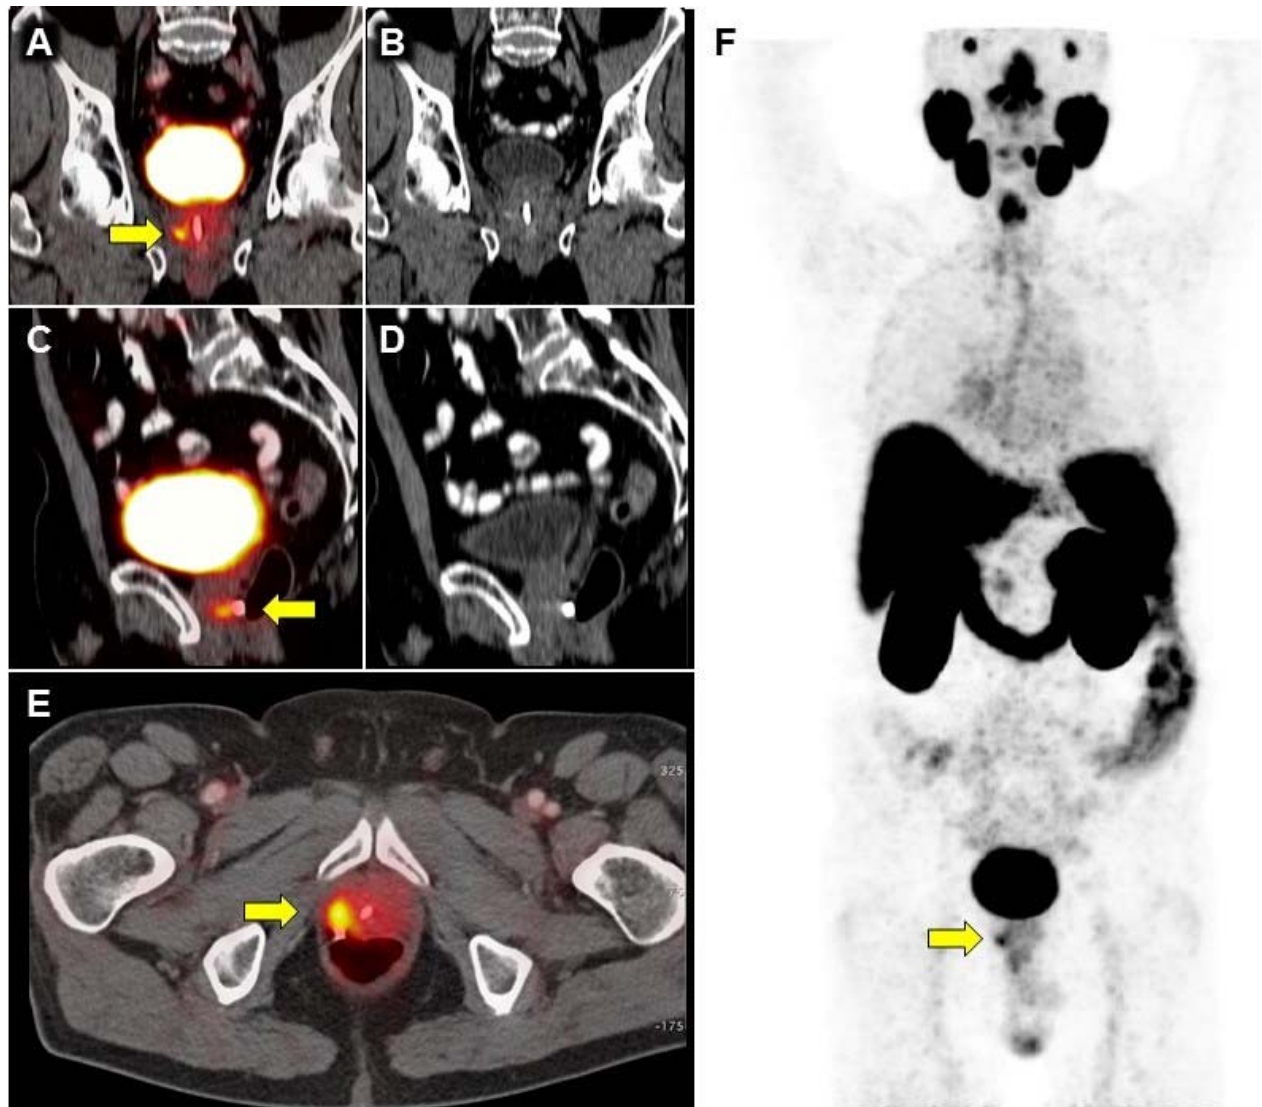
PSMA-11 PET/CT in a 75-year-old patient with BCR (PSA 2.88 ng/ml, doubling time 4.5 months) of an initially high-risk prostate cancer (Gleason 8; pT3) four years after primary radiotherapy without ADT. Q1 listed ADT as planned treatment. PSMA-11 PET/CT showed focal PSMA-11 uptake (SUVmax 3.9) in the right prostate lobe (yellow arrows). The intended treatment after PSMA-11 PET/CT (Q2) was surgery, which the patient refused because of the potential side effects. The actual management was thus ADT as indicated on Q1 (no management change).
